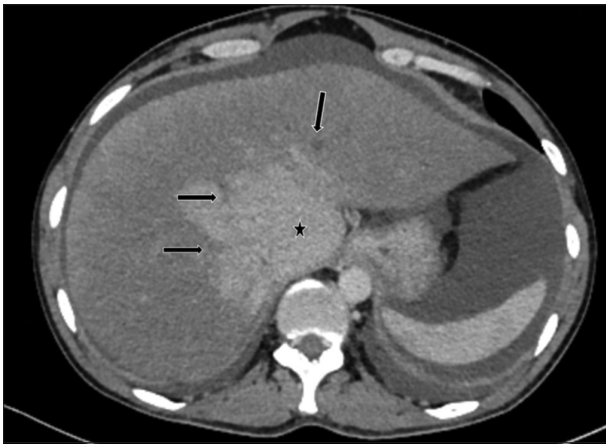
Contrast-enhanced computed tomography abdomen (axial view) showing non-opacification of hepatic veins and hepatomegaly with parenchymal changes consistent with Budd-Chiari syndrome. There is non-opacification of all three hepatic veins (black arrows), indicating hepatic venous outflow obstruction. The caudate lobe and central liver show early enhancement, with delayed enhancement of the peripheral liver, creating a characteristic “flip-flop” appearance (star). The above features are suggestive of Budd-Chiari syndrome
